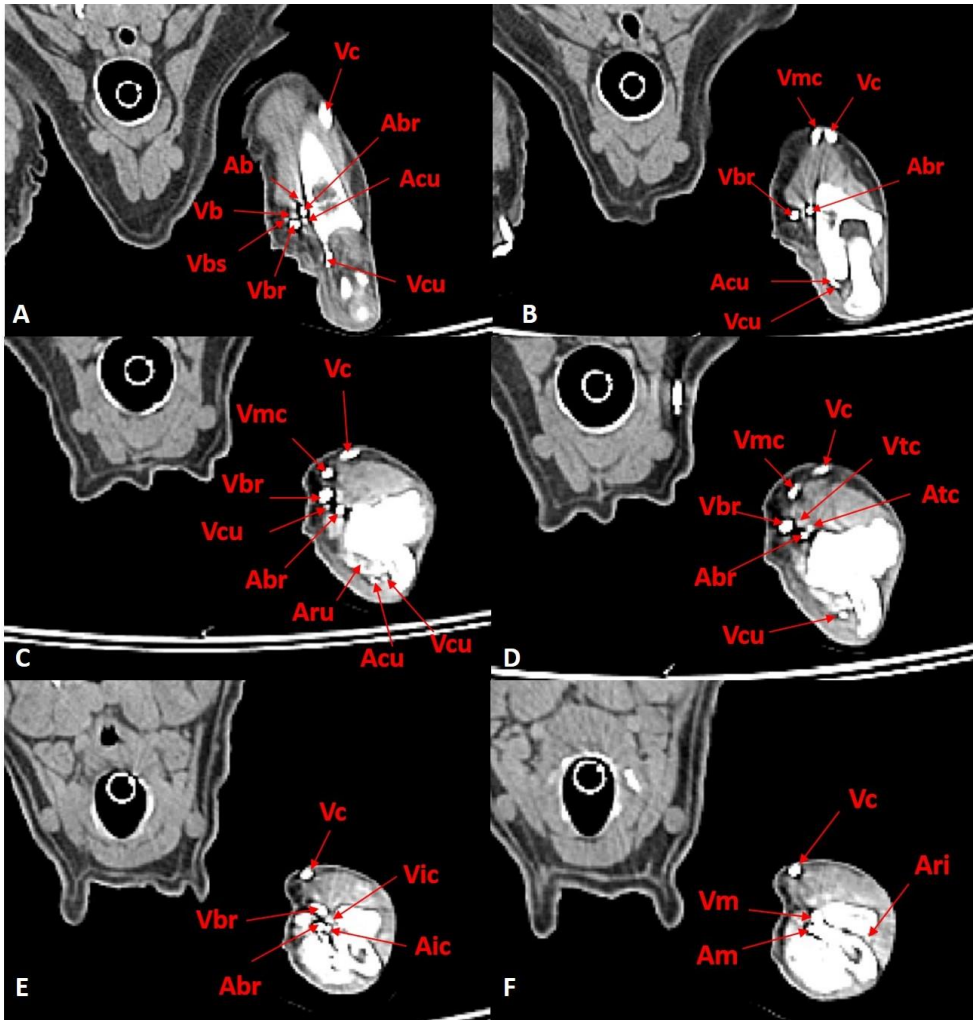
A - CT scan at the level tuber olecranii- Abr – a. brachialis, Vbr – v. brachialis, Vc – v. cephalica, Acu – a. collateralis ulnaris, Vcu – v. collateralis ulnaris, Vbs – v. brachialis superficialis, Ab – a. bicipitalis, Vb – v. bicipitalis; B - CT scan at the level of condylus humeri Abr – a. brachialis, Vbr – v. brachialis, Vc – v. cephalica, Acu – a. collateralis ulnaris, Vcu – v. collateralis ulnaris, Vmc – v. mediana cubiti; C, D - CT scan at the level of trochlea and capitulum humeri - Abr – a. brachialis, Vbr – v. brachialis, Vc – v. cephalica, Vmc – v. mediana cubiti, Aru – a. recurrens ulnaris, Acu – a. collateralis ulnaris, Vcu – v. collateralis ulnaris, Atc – a. transversa cubiti. Vtc – v. transversa cubiti; E, F - CT scan, proximal third of the antebrachium Am – a. mediana, Vm – v. mediana, Vc – v. cephalica, Ari – a. recurrens interossea, Abr – a. brachialis, Vbr – v. brachialis, Aic – a. interossea communis, Vlc – v. interossea communis.
